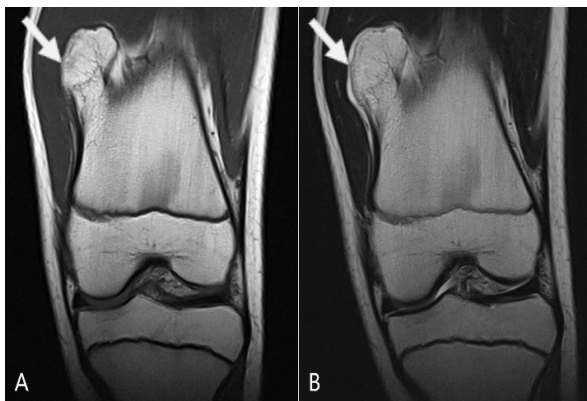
MRI of the left knee in coronal reconstruction. Thin fibrous cartilage cap (arrow) which appears hypointense on (A) T1-weighted image and hyperintense on (B) T2-weighted image.
